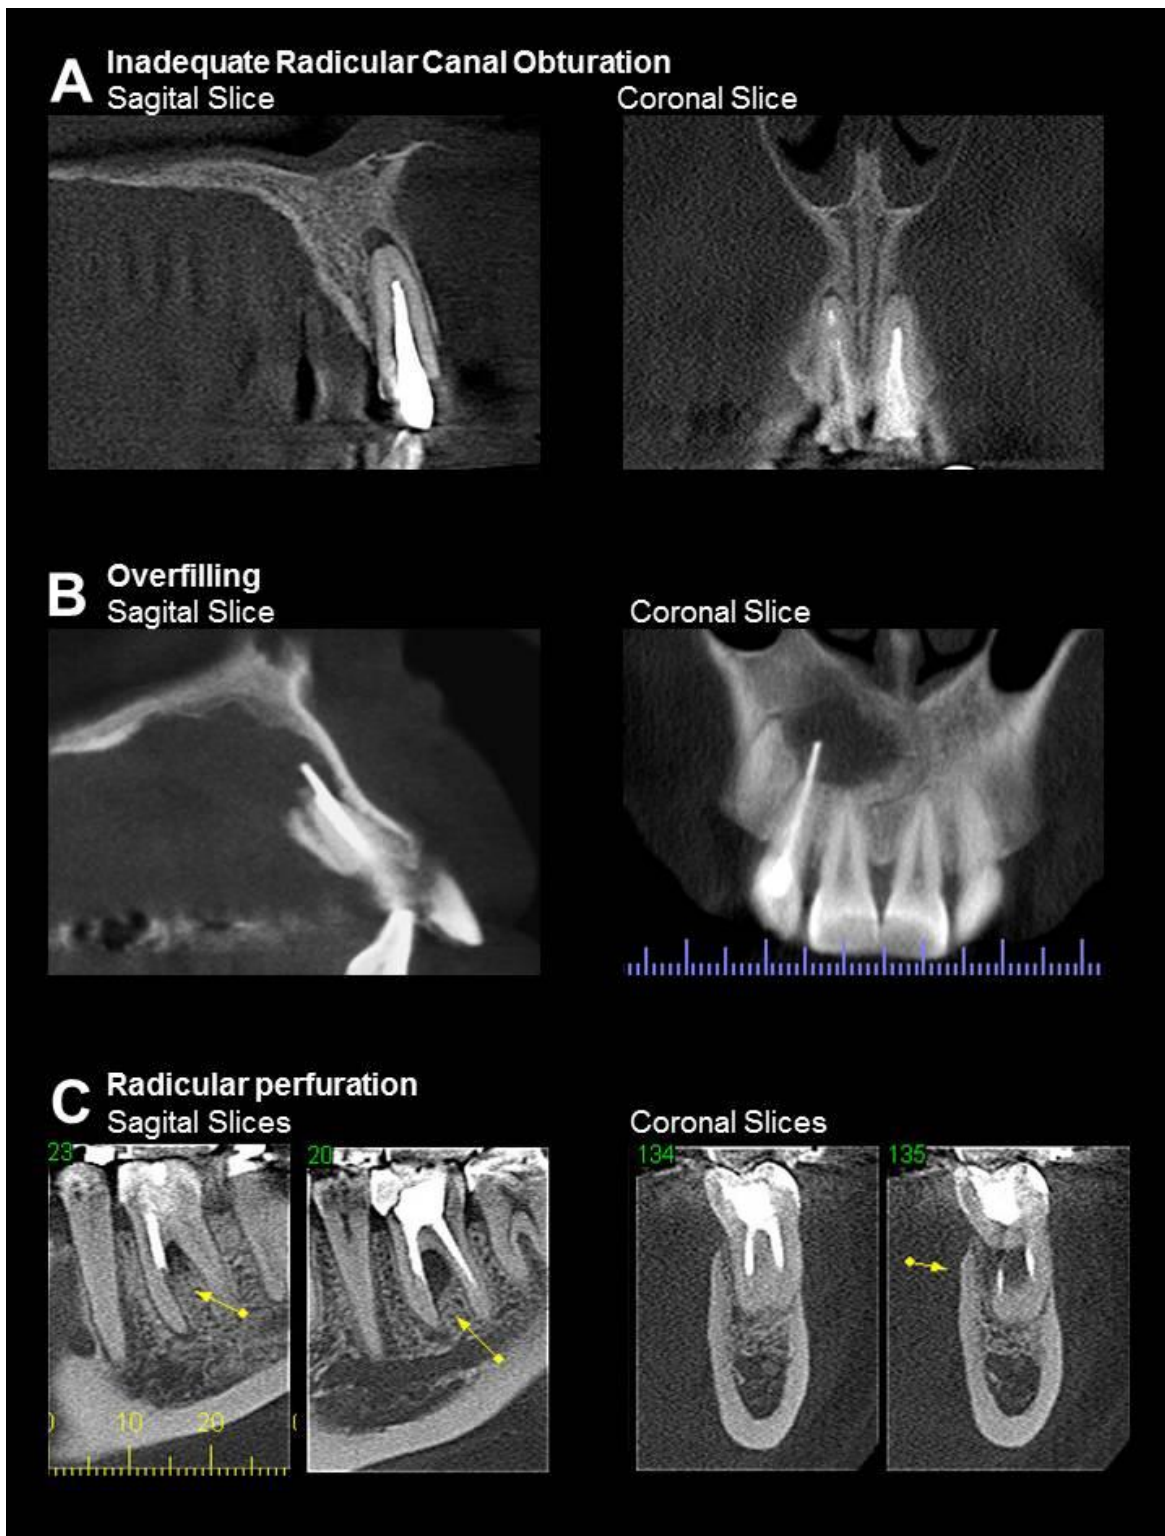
Operatory procedural errors (OPEs) in endodontically treated teeth (ETT): A) Sagittal and coronal slices of maxillary central incisor with underfilling showing periapical radiolucency, B) Sagittal and coronal slices of maxillary lateral incisor with overfilling associated with extensive periapical radiolucency, C) Sagittal and coronal slices of mandibular molar with radicular perforation.
